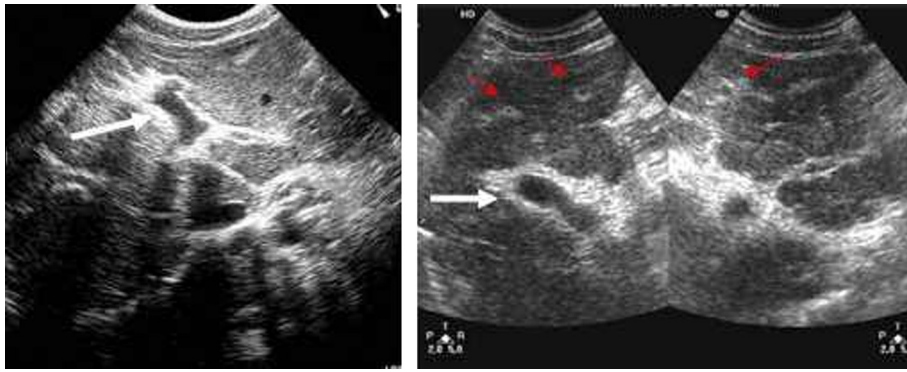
Schistosomal “pipestem fibrosis”. Ultrasonographic images in hepatic schistosomiasis. Note the central periportal fibrosis (white arrow) and fibrosis on the periphery of the liver (red arrows) in a patient with advanced hepatosplenic schistosomiasis [30] (With permission).
